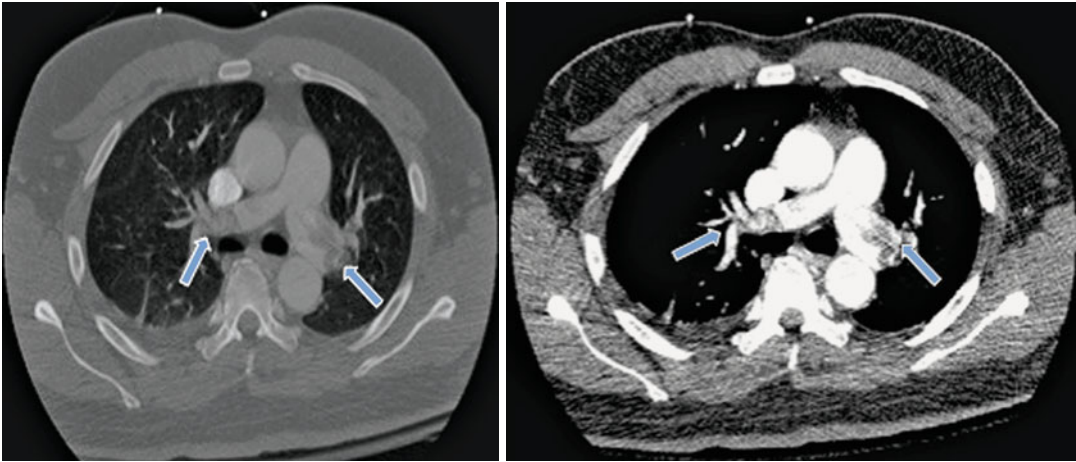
A CT pulmonary angiogram showing a large saddle embolism at the bifurcation of the right pulmonary artery (*arrow*)
